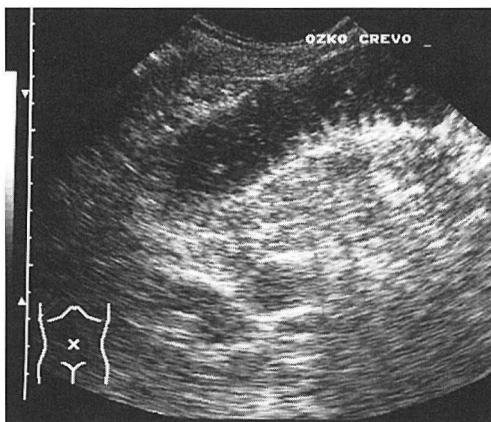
Ultrasonogram showing dilated fluid-filled loop of the small bowel with thickened wall and swollen mucosal folds.
